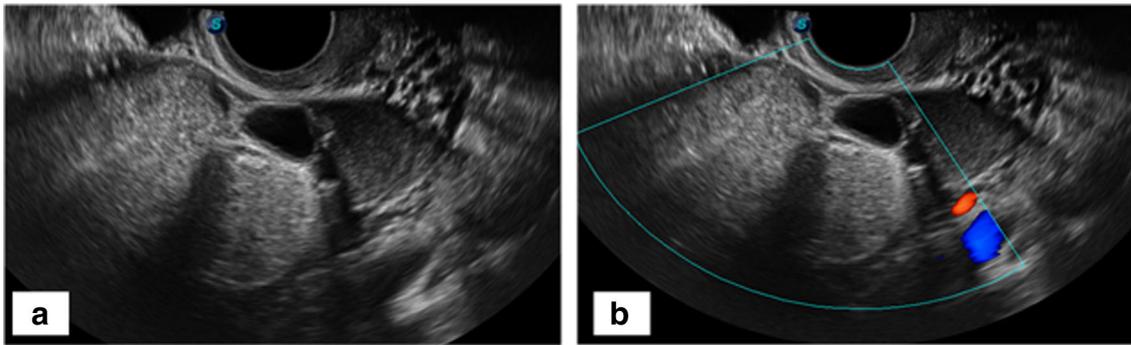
a Transvaginal ultrasound demonstrates a right adnexal complex mass. The mass shows highly echogenic content with posterior shadowing. b Color Doppler study demonstrates no vascularity. The
